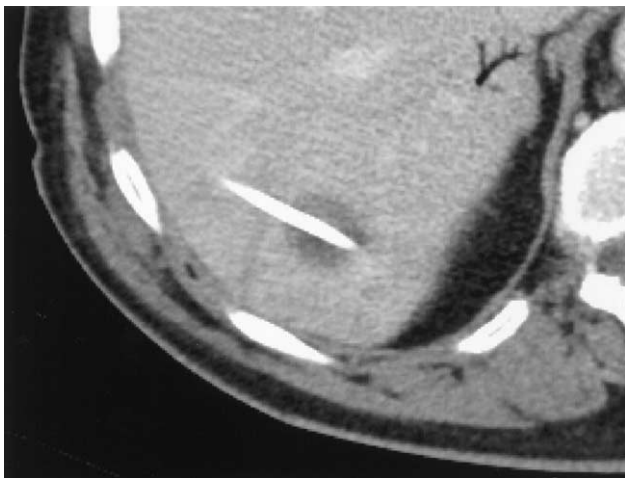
Contrast-enhanced computed tomography (CT) after CT-guided positioning of a brachytherapy catheter in a metastasis of a colorectal carcinoma.
